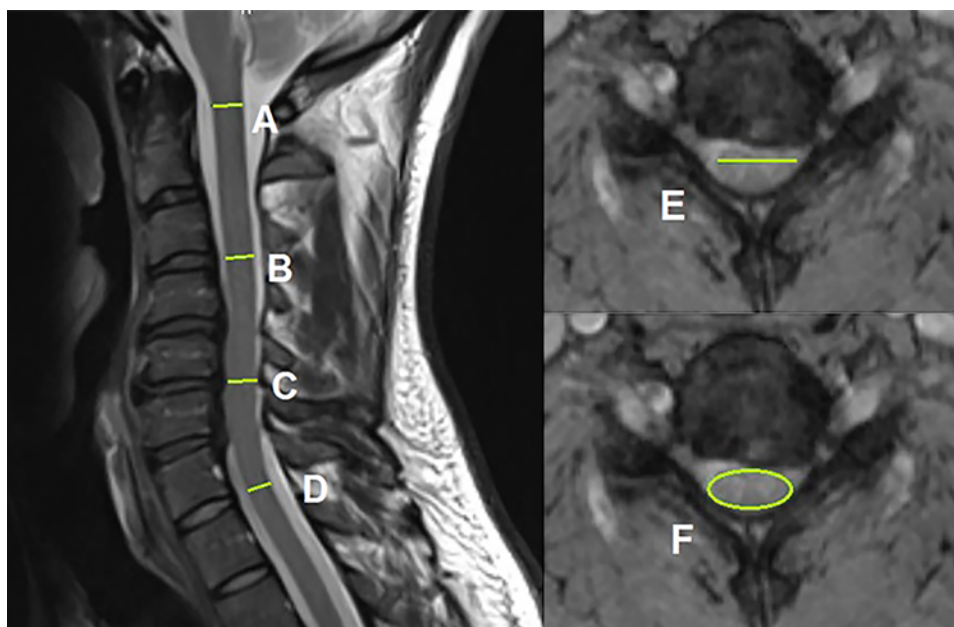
Measurements from sagittal (left) and transverse (right) views of T2-weighted MRI of the cervical spinal cord. These measurements include lines marked A: diameter of cord at the level of C1 vertebra; B: diameter of cord at the first level superior to the LMC that is normal; C: diameter of cord at the LMC; D: diameter of cord at the first level inferior to the LMC that is normal; E: transverse diameter of cord at the LMC; and F: transverse area of cord at the LMC (circle).
